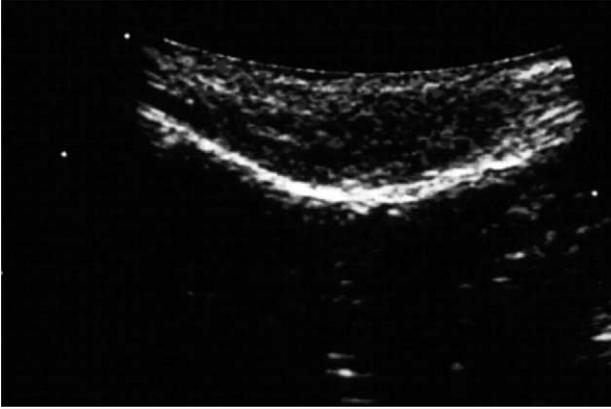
Ultrasound image of an unfractured lateral orbital wall. The lateral orbital wall shows a continuous convex structure.
